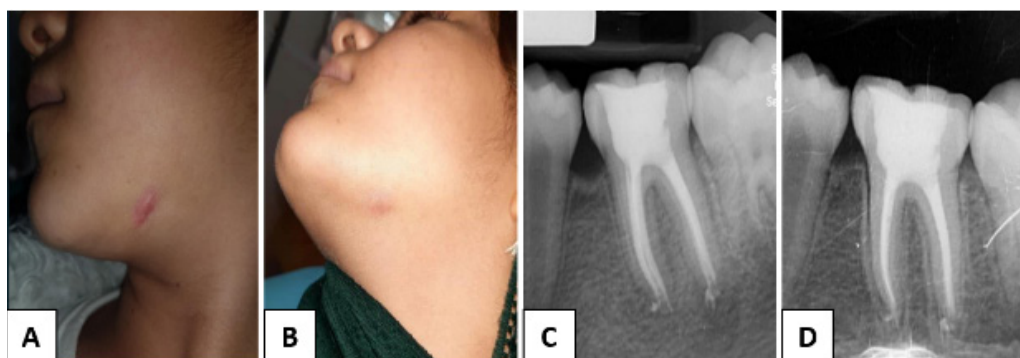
Follow up. A) 6-month follow-up extra-oral photograph; B) 12-month follow-up extra-oral photograph; C) 6-month follow-up radiograph; D) 12-month follow-up radiograph
